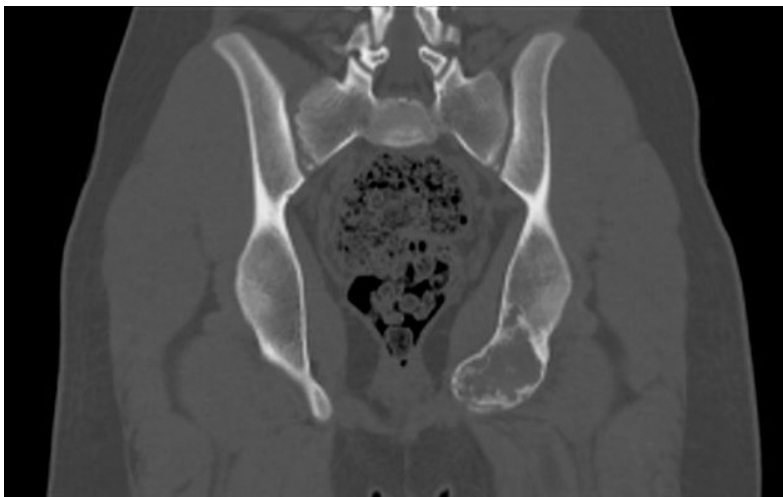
CT scan of an 8-year-old male with aneurysmal bone cyst of the left ischium. Coronal view shows a large, expansile, lucent bone lesion in the left inferior pubic ramus and ischium with internal septations. Margins are well-defined and measures approximately 4.5 x 2.9 x 8.3 cm. Image courtesy of Dr. David Cuete. <https://radiopaedia.org/cases/aneurysmal-bone-cyst-of-ischium?lang=us>
